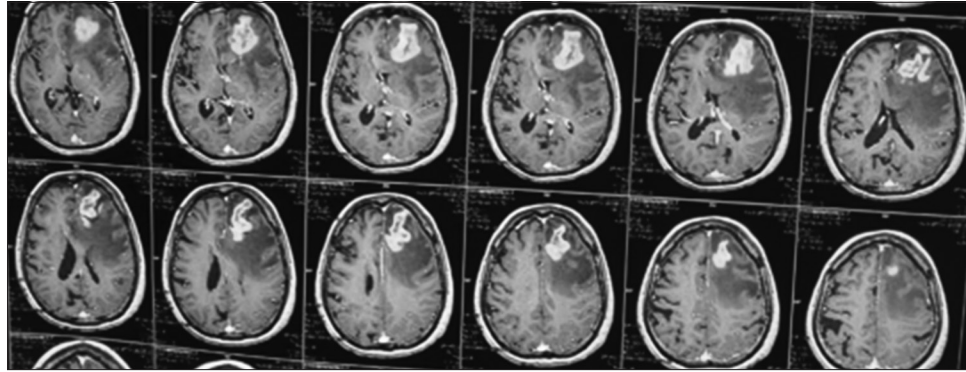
MRI Brain (T1 contrast) showing irregular contrast enhancing mass lesion in the left frontal lobe with mass effect.
